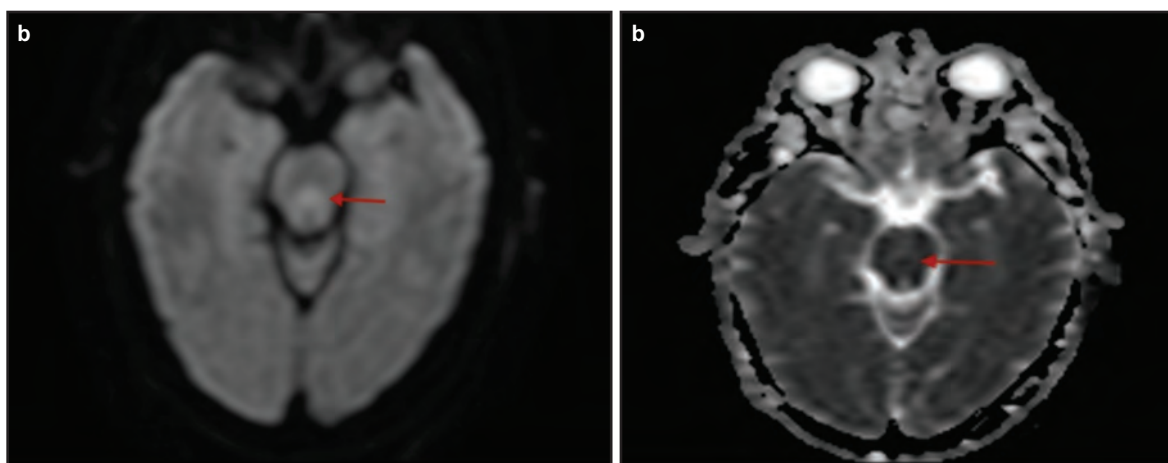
a&b : DWI/ADC sequence showing small foci of Hyperintense signal/restricted diffusion at the central pontine.
